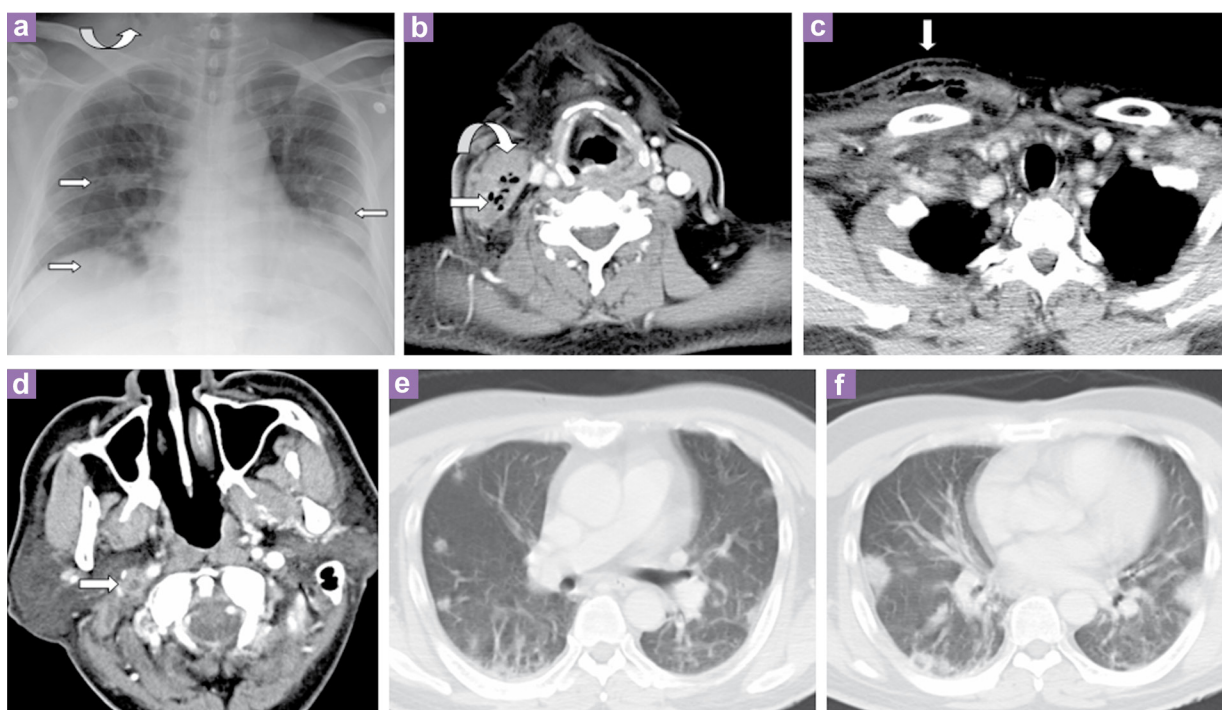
(a) Antero-posterior (AP) supine chest radiograph at presentation: a few airspace opacities and lung nodules was observed in both lung fields (straight arrows). Soft tissue emphysema was noted at the right neck root (curved arrow). (b) Contrast-enhanced computed tomography (CT) images showing an ill-defined heterogeneously enhancing lesion with debris, collections and emphysematous changes on the right side of the neck posteromedial to the right sternocleidomastoid muscle (straight arrow). The right sternocleidomastoid muscle was heterogeneously enhanced (curved arrow). (c) The lesion extending to the right supraclavicular fossa and anterior chest wall. The investing cervical fascia was thickened. There was adjacent fat streakiness with thickened, enhanced overlying skin (arrow). (d) Contrast-enhanced CT image, axial slices showing right internal jugular vein (IJV) thrombosis (arrow). (e,f) CT images showing multiple peripheral lung nodules with varying sizes and consolidation in both lung fields. Some of the consolidations were sub-pleural, wedge-shaped, with apices directing towards the hila.
